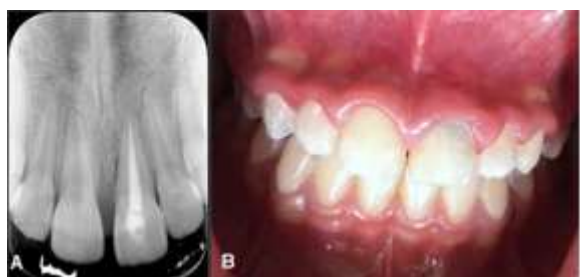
Six-month follow-up. (A) Radiograph shows formation of lamina dura and bone formation in the affected areas. (B) Normal gingival tissue and absence of sinus tract are evident.
